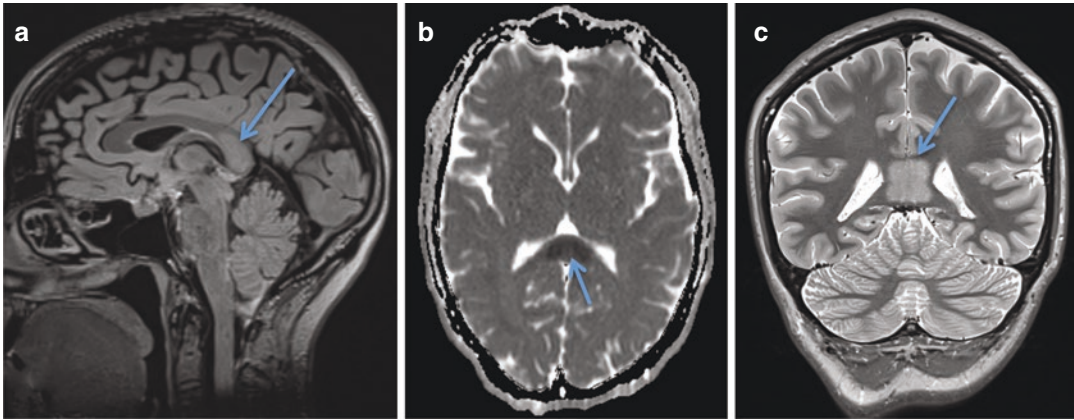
MERS type 1 in a 36-year-old presurgical epilepsy patient. The FLAIR (a: arrow)/T2 (c: arrow) hyperintense splenium lesion has a typical location and configuration and shows a distinct DWI reduction (b: arrow). It was incidentally detected and most likely due to
